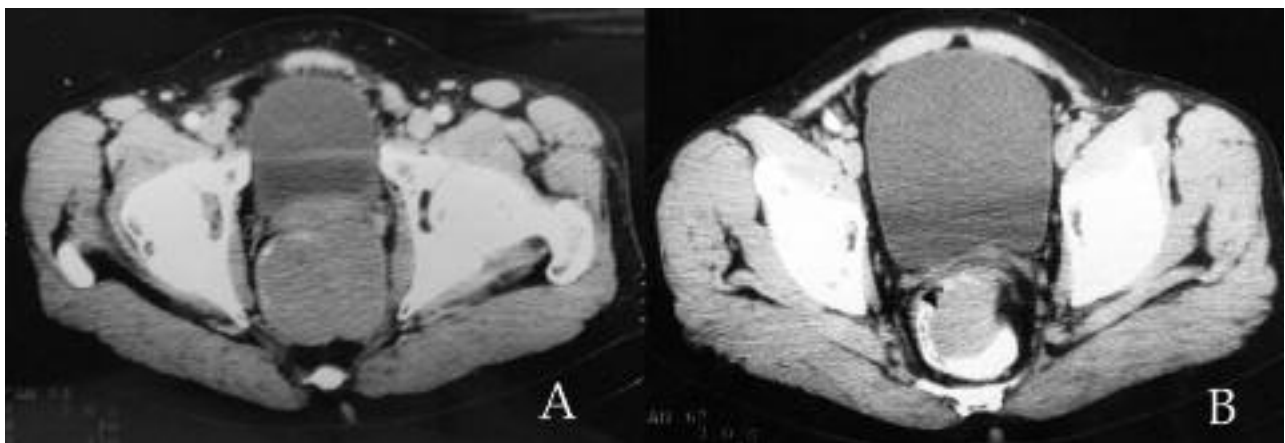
Case 2. A : CT scan of the pelvis showing a large mass in the lower rectum ; B : Remarkable response on MRI in tumor size after 9 months treatment with imatinib.
